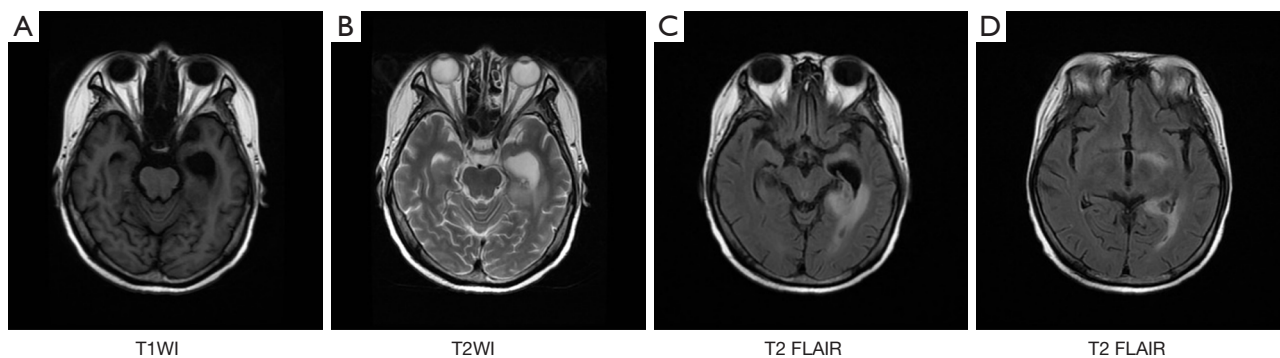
The patient's cranial MRI. (A-D) Cranial MRI of the patient on the 10th day after admission: there are lesions in the posterior horn of the left lateral ventricle, adjacent temple, and occipital lobes with irregular shape and blurred borders. The T1WI shows low signal, and T2 FLAIR showed high signal with the enlargement of the inferior horn of the left lateral ventricle, whereas the posterior horn of the lateral ventricle shows a heterogeneous signal. The midline structure is not displaced. The remaining ventricular system is normal in size and morphology with no abnormal signal shadows. MRI, magnetic resonance imaging; T1WI, T1 weighted imaging; T2WI, T2 weighted imaging; FLAIR, fluid-attenuated inversion recovery.
